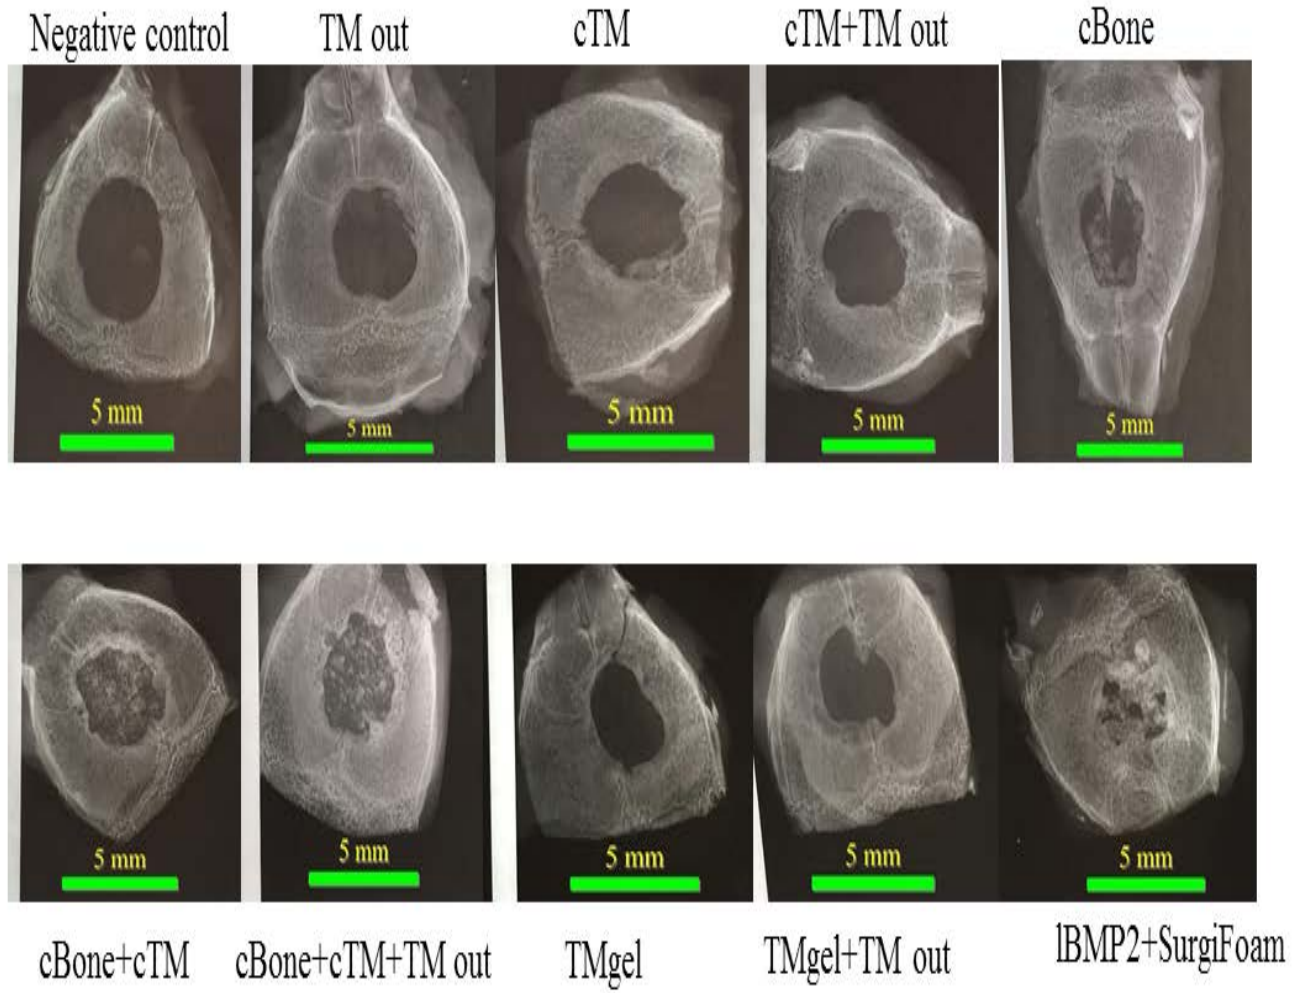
Representative radiographs
